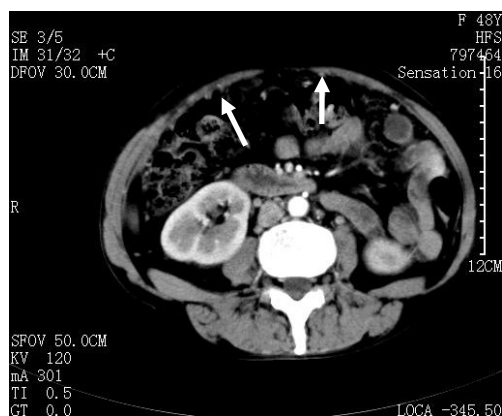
Computed tomography (CT) scans of the abdomen and pelvis
